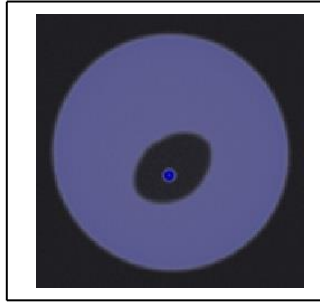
Using air, top view of X-ray image for 3ml of air injected in PVA hydrogel (Sample 1).
